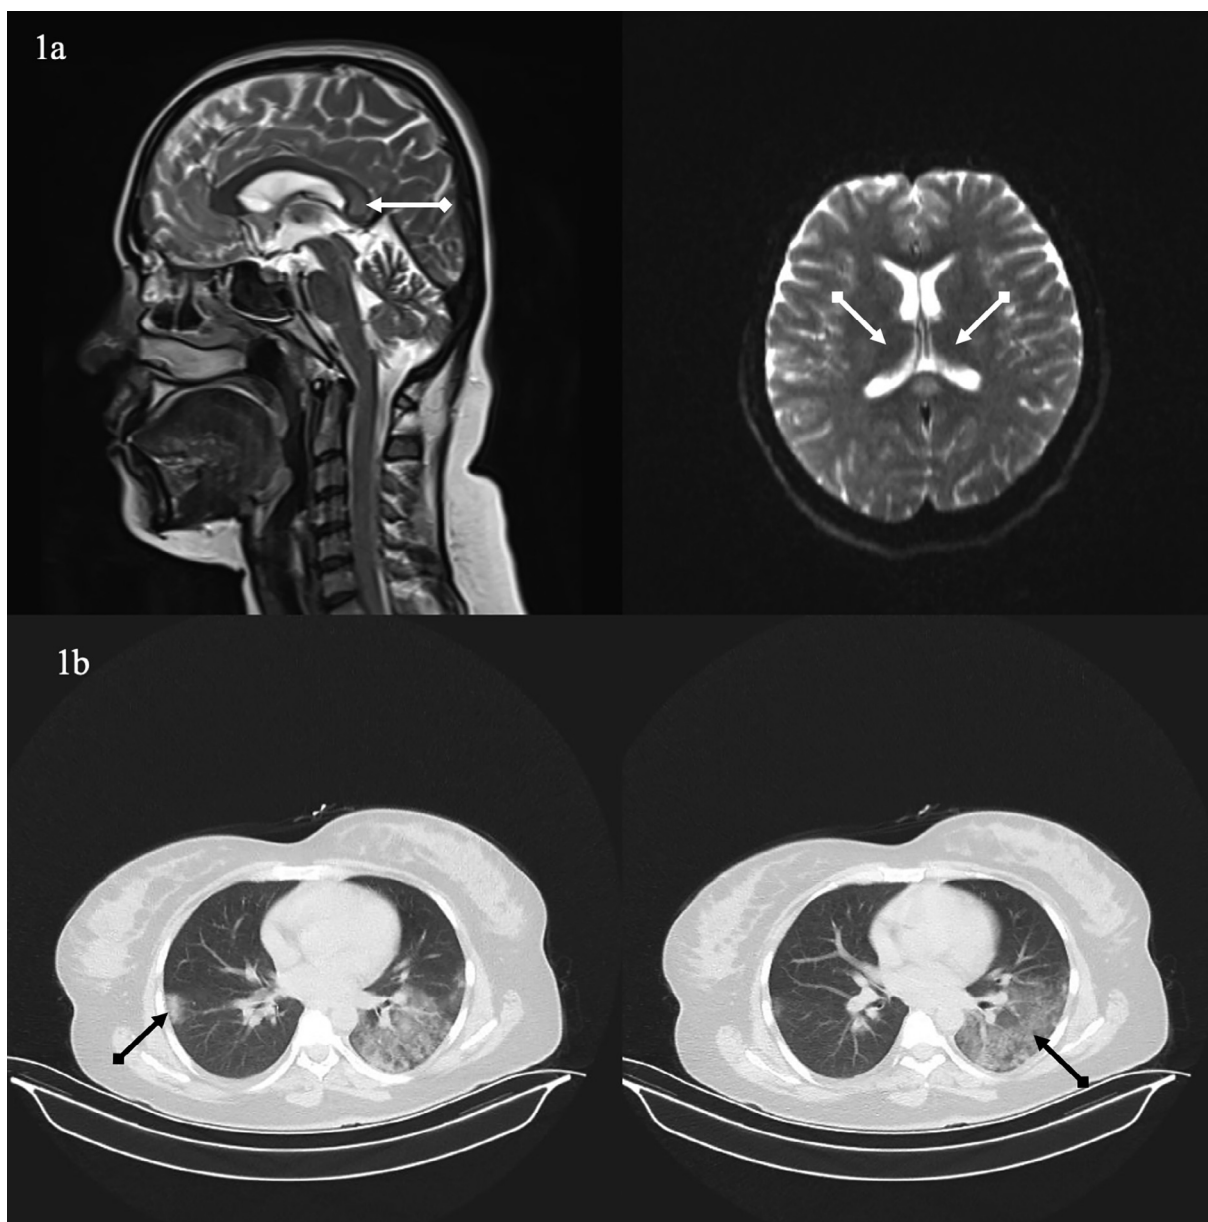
a: MRI of the brain showed hyperintense signal in the splenium of the corpus callosum with decreased apparent diffusion coefficient, which possibly indicates the presence of cytotoxic edema on brain MRI, 1b: CT scan of the chest showed bilateral ground-glass opacities.
